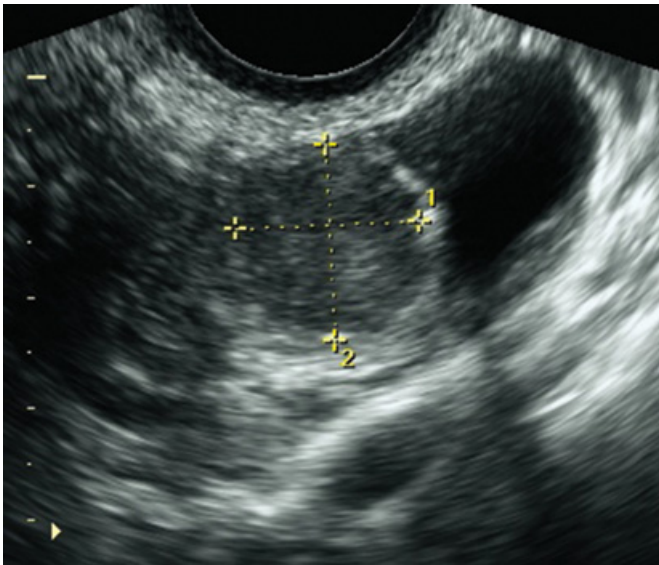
Corpus luteum, haemorrhagic cyst and endometrioma may have a similar appearance on ultrasound.
